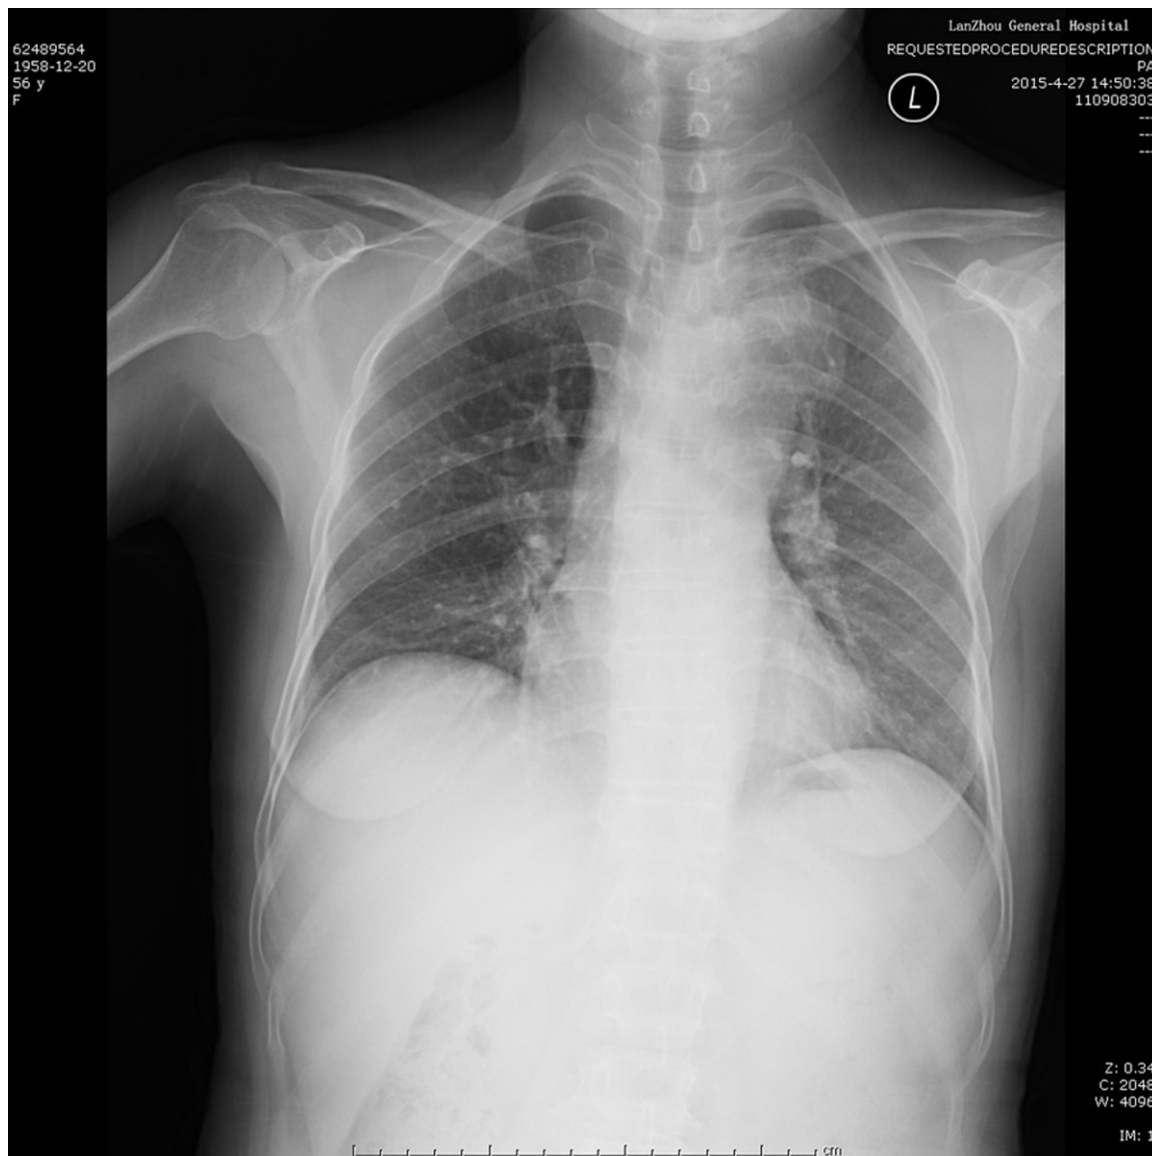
A chest X-ray showed left widened mediastinum and an irregular shadow on the outside the top of left lung and aortic arch.
